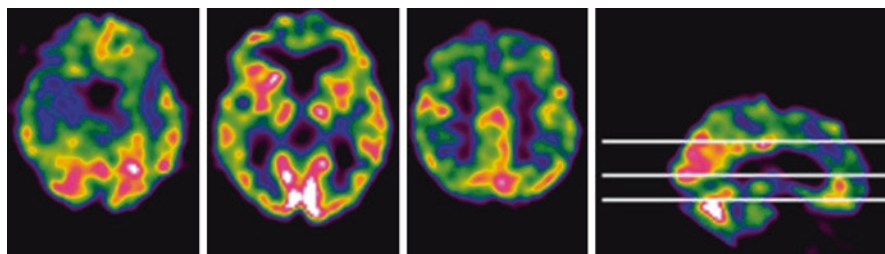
Perfusion SPECT (^{99m}Tc -HMPAO) showed in three transaxial sections in an 82-year-old woman (15 years of full education) with aMCI (Mini-Mental State Examination score 27/30, no impairment in autonomy in everyday life activities). The scan shows reduced tracer uptake in the medial temporal lobe (on *left*), lateral temporal cortex (*middle*), and posterior cingulate cortex (*right*) in the right hemisphere
